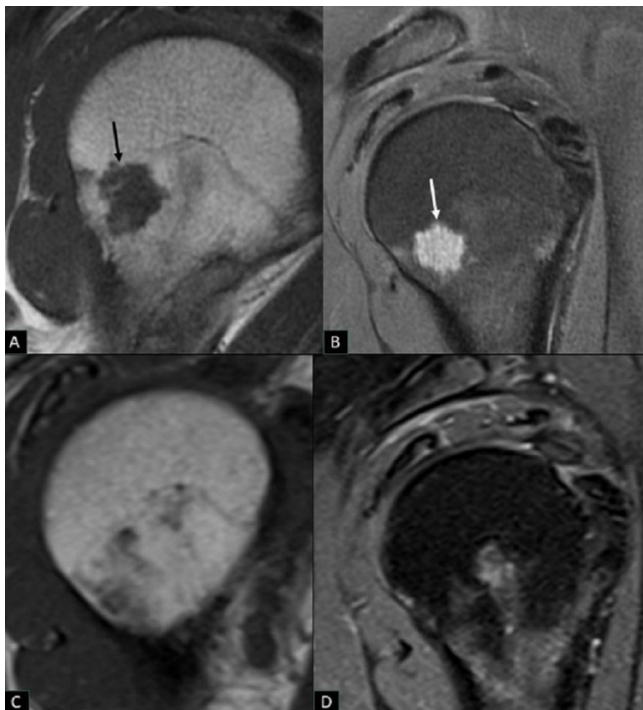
Sagittal T1-weighted (A) and PD fat saturated images (B) of the shoulder demonstrates well-defined intramedullary lesion in the proximal humeral meta-diaphysis, which is hypointense on the T1 weighted image (black arrow) and hyperintense on the PD fat saturated image (white arrow). There is no perilesional edema or cortical destruction or extraosseous soft tissue component. Follow-up sagittal T1-weighted (C) and STIR (D) MRI images of the left shoulder 8 years later shows complete resolution of the lesion.
